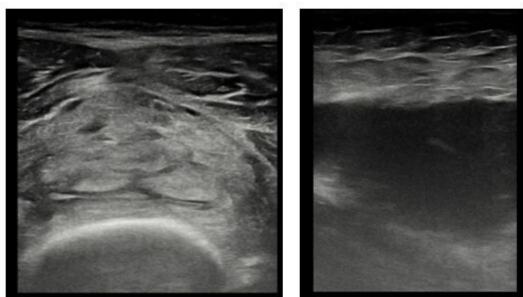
Ultrasound evolution of a vastus medialis haematoma in a young athlete. Left panel (acute phase, transverse view): a hyperechoic area is visible, consistent with recent haemorrhage and clot formation. Right panel (subacute phase, longitudinal view): the haematoma has become predominantly anechoic, indicating progressive liquefaction and resorption.
